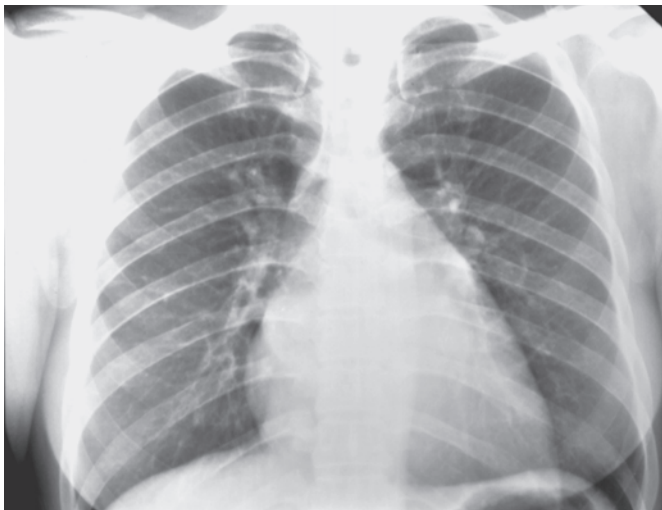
Chest radiograph from a patient with severe mitral stenosis, showing a typical straight left heart border, prominent pulmonary artery, large left atrium, right ventricular contour, and pulmonary venous hypertension.
